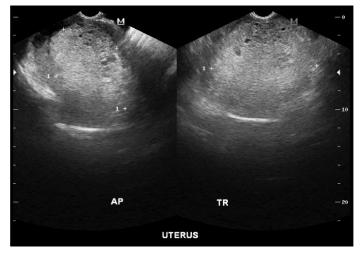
Transvaginal ultrasound of the patient revealing a heterogenous mass with multiple sonuluscent cystic spaces measuring $10.7 \times 10.8 \times 6.9$ cm (volume of 418cc) occupying the endometrial cavity.
